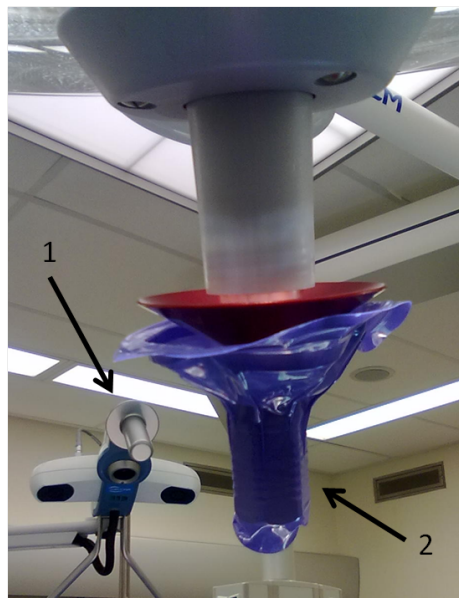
Example of implementation of sterile handle with sterile cover. (1) shows the handle of the freehand SPECT device without cover and (2) shows a lamp with the selected cover.
